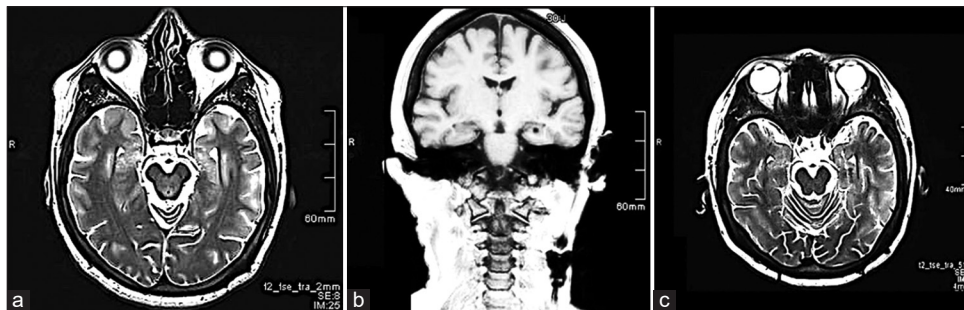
(a) Preoperative T2-magnetic resonance imaging (MRI), axial view showing left hippocampal atrophy and increased diameter of the temporal horn with no evidence of structural lesion. (b and c) Postoperative MRI, T1-coronal, and T2 axial view, showing electrode position in the left hippocampus.
